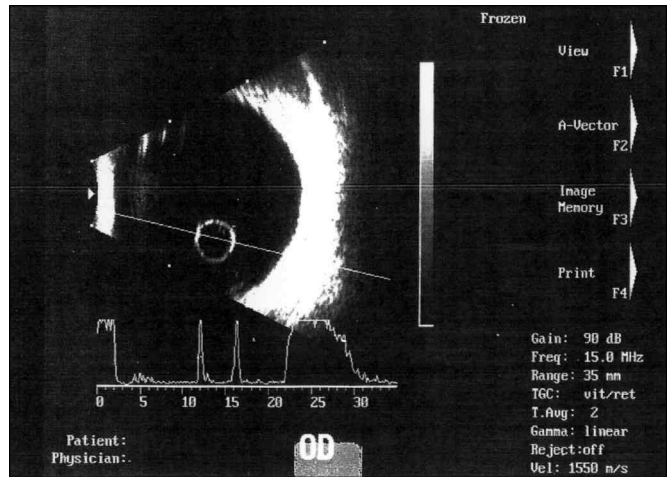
Thin-walled, spherical, hypoechoic cyst on B-mode ultrasonography.
